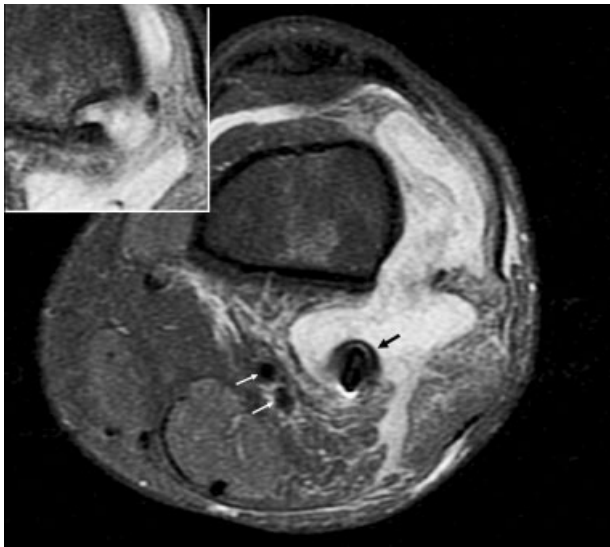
MRI at 6 months after the ACL reconstruction showed a 79 × 60 × 17 mm multilobulated tumor. The implant device (black arrow) was observed in its posteriormost area. See its close proximity to the popliteal vessels (white arrows). The tumor looked as if it had originated from the eroded exit of the femoral tunnel (see upper left corner). ACL, anterior cruciate ligament; MRI, magnetic resonance imaging.
